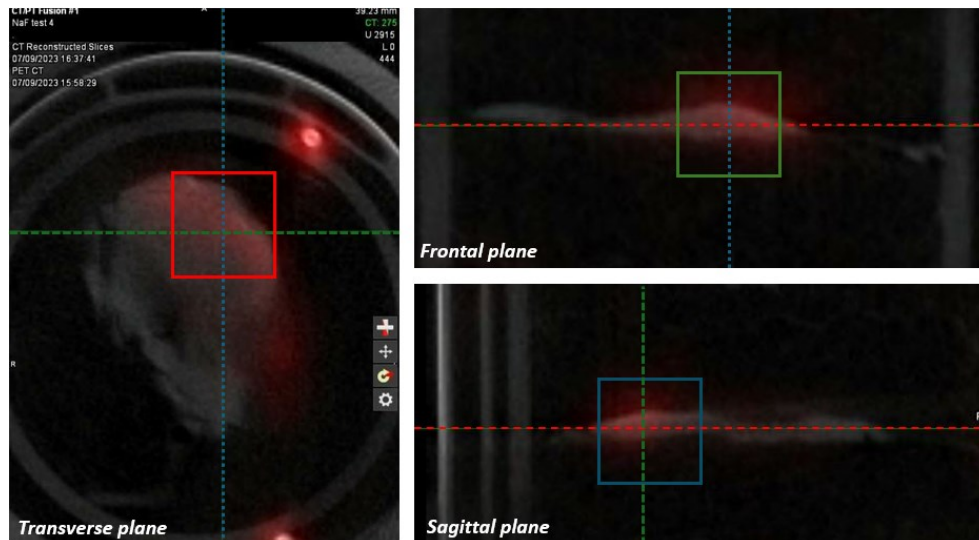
PET+/CT- mismatch region indicating the presence of a microcalcification area detected by the ^{18}F -NaF tracer in a homograft.
